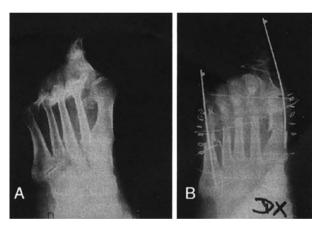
A) Pre-operative X ray; B) Post-operative X-ray showing substitution of II, II, III and IV metatarsophalangeal joints
